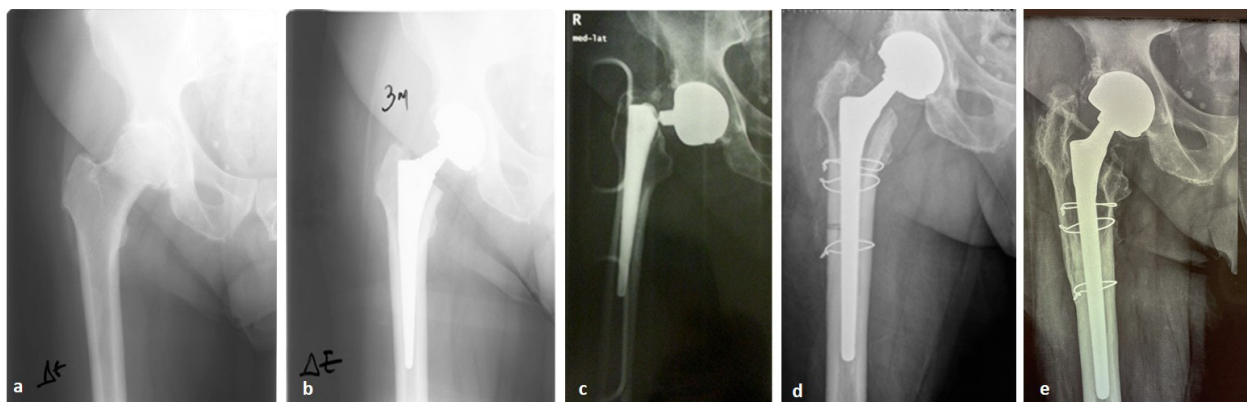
(a) preoperative x-ray of a 64-year-old patient with osteoarthritis of the hip, (b) 3-month postoperative x-ray after THA implantation, (c) fracture of the femoral neck at 5 years postoperatively, (d) 1-month postoperative x-ray after revision surgery with a Wagner type stem and extended osteotomy and (e) last follow up x-ray at 11 years post-revision.
